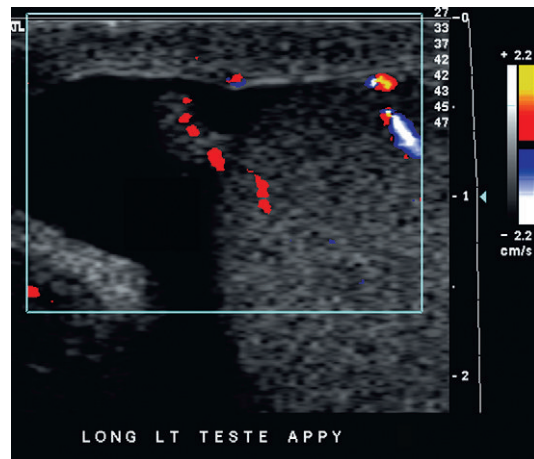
A longitudinal view of the left testes at the area of maximum tenderness in this patient. The appendix testis was conspicuous as the focus of pain. Note the hyperaemia at the base of this structure. It is quite rare to actually identify colour Doppler flow abnormalities in the appendix testis. Typically patients present well after the structure has necrosed and sloughed.
